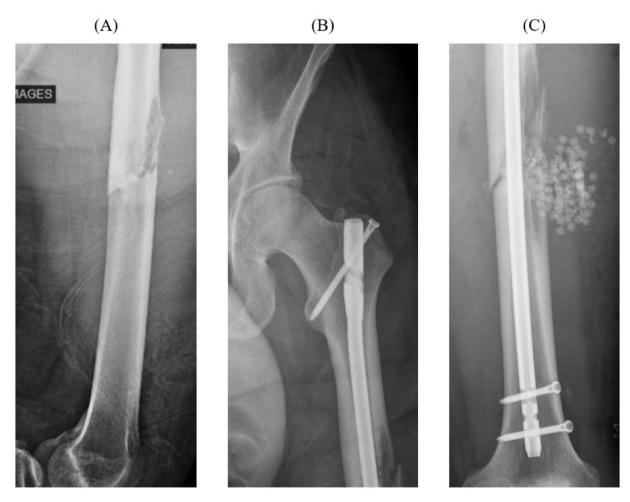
A: Xray (lateral). Pathological fracture of mid diaphysis of left femur. B: Xray (anteroposterior). IMN with interlocking screws. C: Xray (anteroposterior). IMN with interlocking screws and antibiotic beads with alignment of mid diaphysis fracture. IMN= Intramedullary nail.
